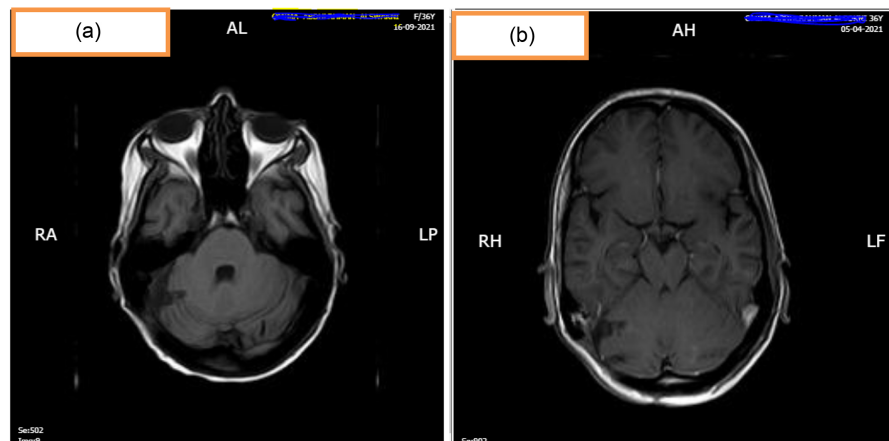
Post-operative MRI shows total resection of tumor with no detectable enhancement in the right CP angle promptly after surgery (a) and one-year post-operation follow-up (b).
